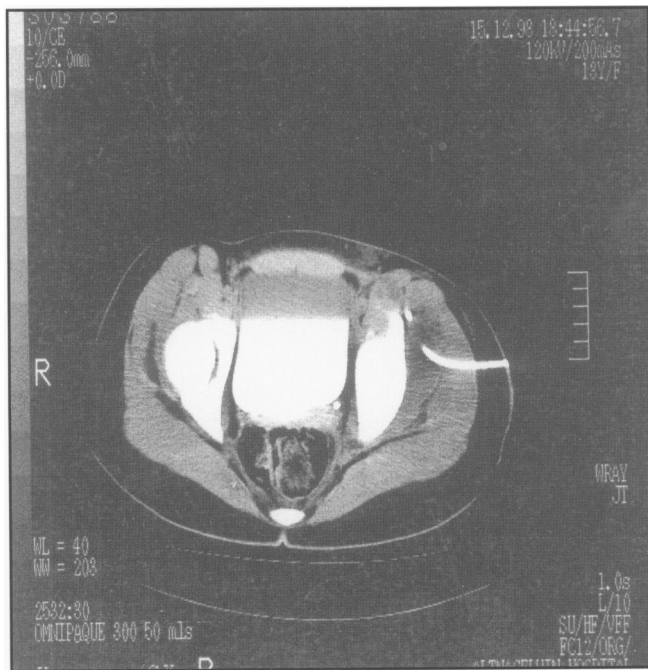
CT-guided percutaneous aspiration of gluteal abscess.
